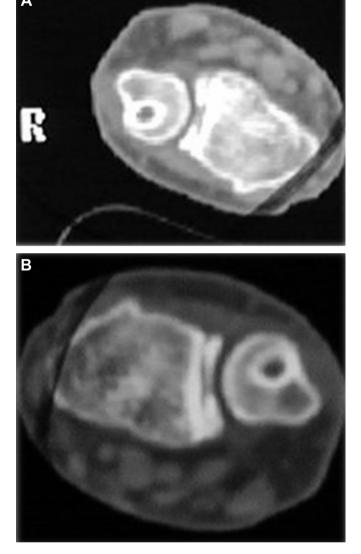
(A, B) Postoperative computed tomography (CT) of the wrist in supination and pronation positions demonstrate good distal radioulnar joint (DRUJ) congruency and no motion limitation.
